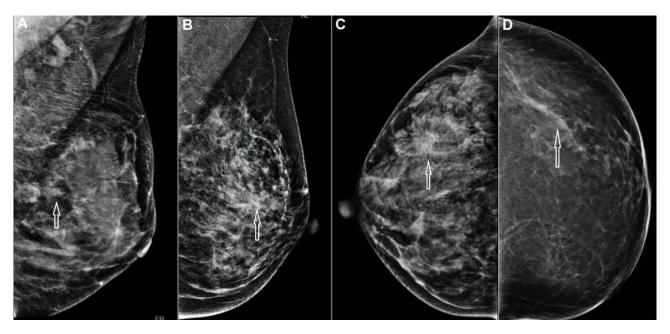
Depiction of Molybdenum Target X-ray Signs. (A) Calcification (arrow); (B) Distorted or Asymmetrical Structure (arrow); (C) Distorted or Asymmetrical Structure with Calcification (arrow); (D) Unilateral Ductal Dilatation (arrow).
